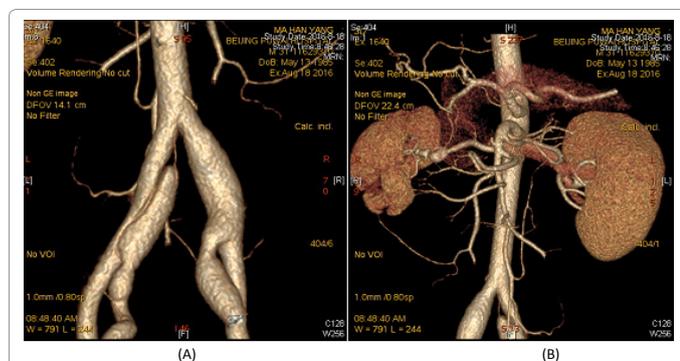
Contrast-enhanced computed tomography scan and three-dimensional reconstruction of the whole aorta. (A) Aneurysm involving the right common and internal iliac artery, and left common iliac artery dissection. (B) Aneurysm continued with stenosis of distal segment of right renal artery and small-sized right kidney.
